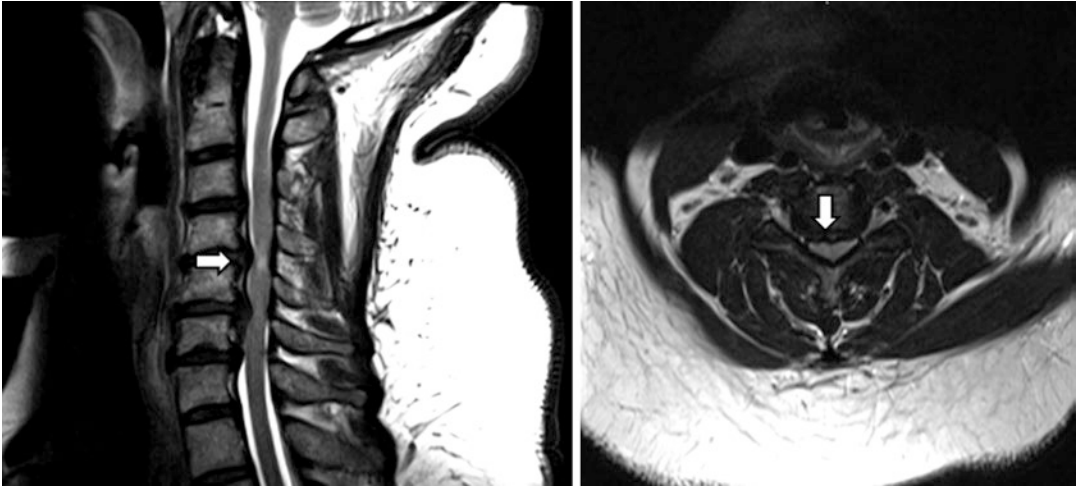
MRI demonstrating multilevel disc-osteophyte complexes (*arrow*) causing canal stenosis and spinal cord compression. T2 signal change within the spinal cord suggests pathologic changes that correlate with myelopathy
